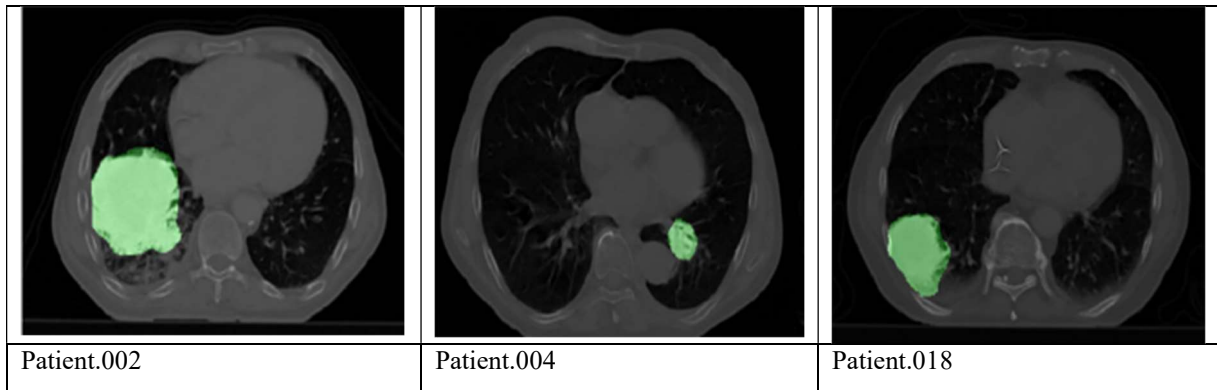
CT Scan Samples from the NSCLC-Radiomics Dataset with Tumor Segmentations
